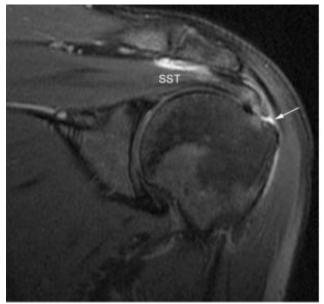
Coronal oblique fat-saturated T2-weighted MR image shows a bursal-surface partial-thickness tear in the distal supraspinatus tendon.
